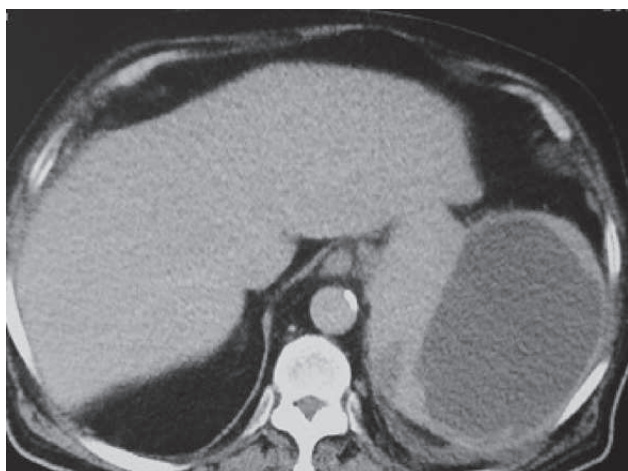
Abdominal computed tomography in a 71-year-old male depicting a massive splenic infarct 13.5×10.6 cm with septae.
